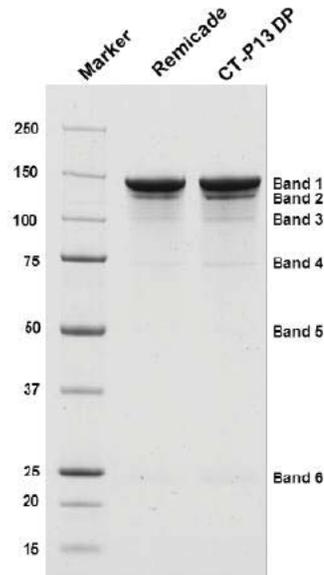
R-61: Non-Reduced SDS-PAGE Gel Image of CT-P13 Drug Product (B11R003, 4 µg) and EU-approved Remicade® (9RMA61401, 4 µg)
